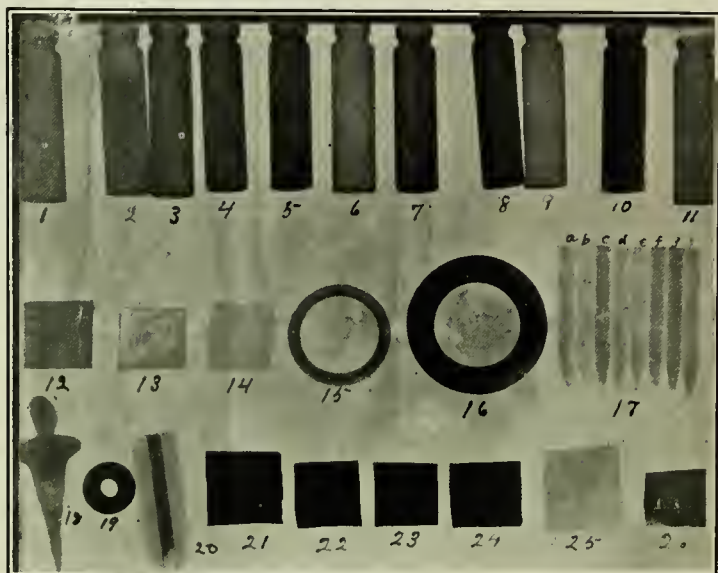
Showing the Relative Penetration by the X-Ray of Different Metals, Colored Solutions, and Other Substances; Indicating that no Law of Specific Gravity or Density Governs Transmission.
